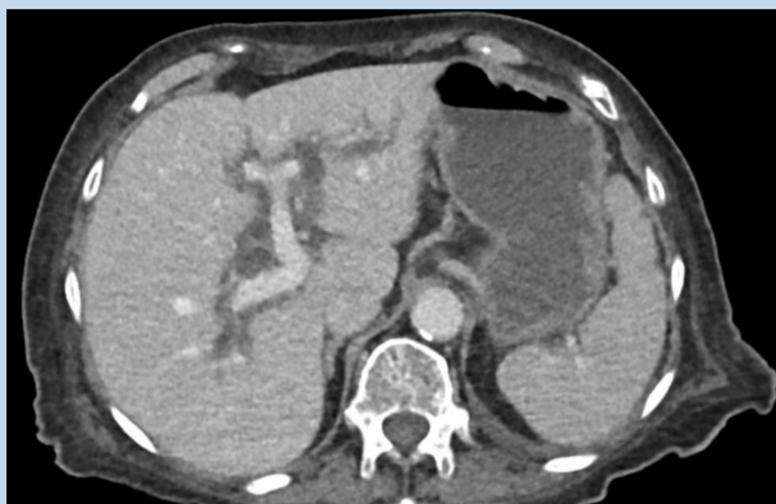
Abdominal CT showing dilation of intrahepatic and extrahepatic ducts with inflammation of biliary tree. Note of possible co-existing pathologies such as hepatic or pancreatic tumors.
